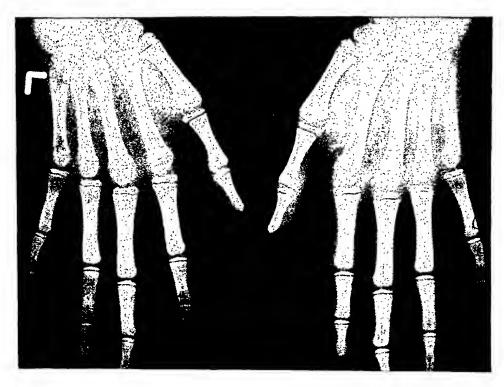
Case 11. Roentgenograms of hands showing unusual length of digits and metacarpal bones.
